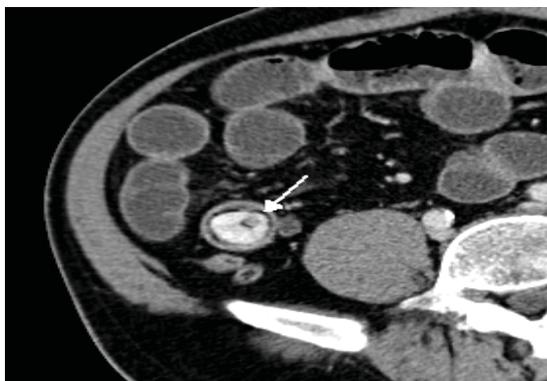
Axial CT shows a laminated intra-luminal obstructive mass with a low-density central nidus and a thin high-density rim.
